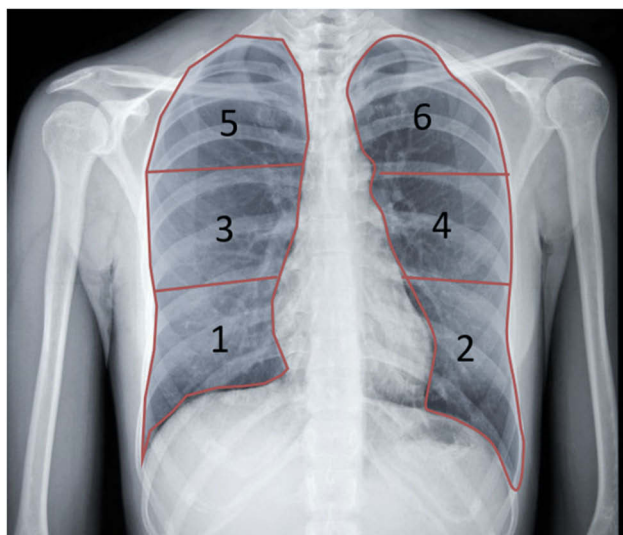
Lung field division using Modified Chest X-ray Scoring System on chest posteroanterior (PA) projection. The lung field is divided into six zones lower zone (1 or 2) is under the inferior wall of the lower right pulmonary vein (lung base), middle zones (3 or 4) is below the inferior wall of the aortic arch and above the inferior wall of the lower right pulmonary vein (ie, hilar structures), and upper zone (5 or 6) is above the inferior wall of the aortic arch.
